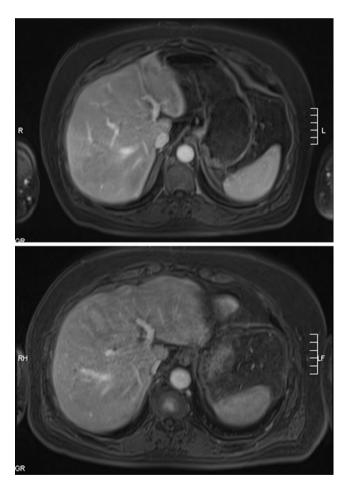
Venous phase magnetic resonance imaging demonstrating hypertrophy of left lower and middle segments at 12 months after initial operation (*bottom image*) when compared with image from the same patient at 2 months after initial operation (*top image*)
